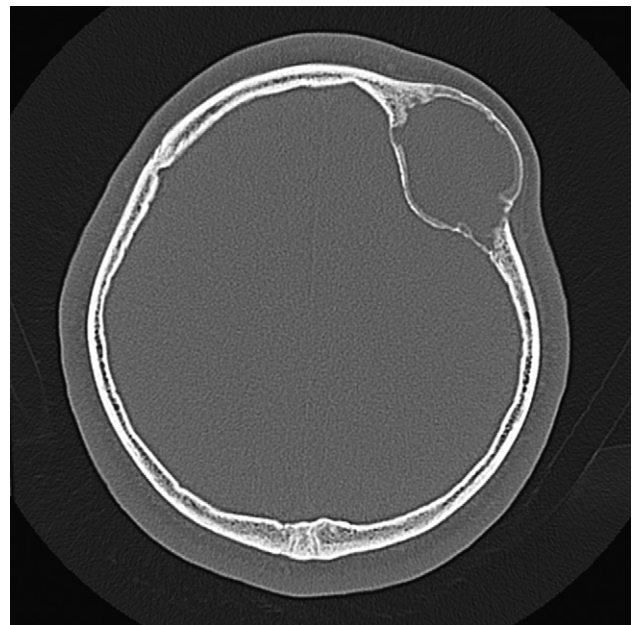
Preoperative computed tomography without contrast medium showing a well-demarcated, intradiploic mass of the frontal and left parietal bone. The inner and outer cortical plates are maintained despite thinning.
